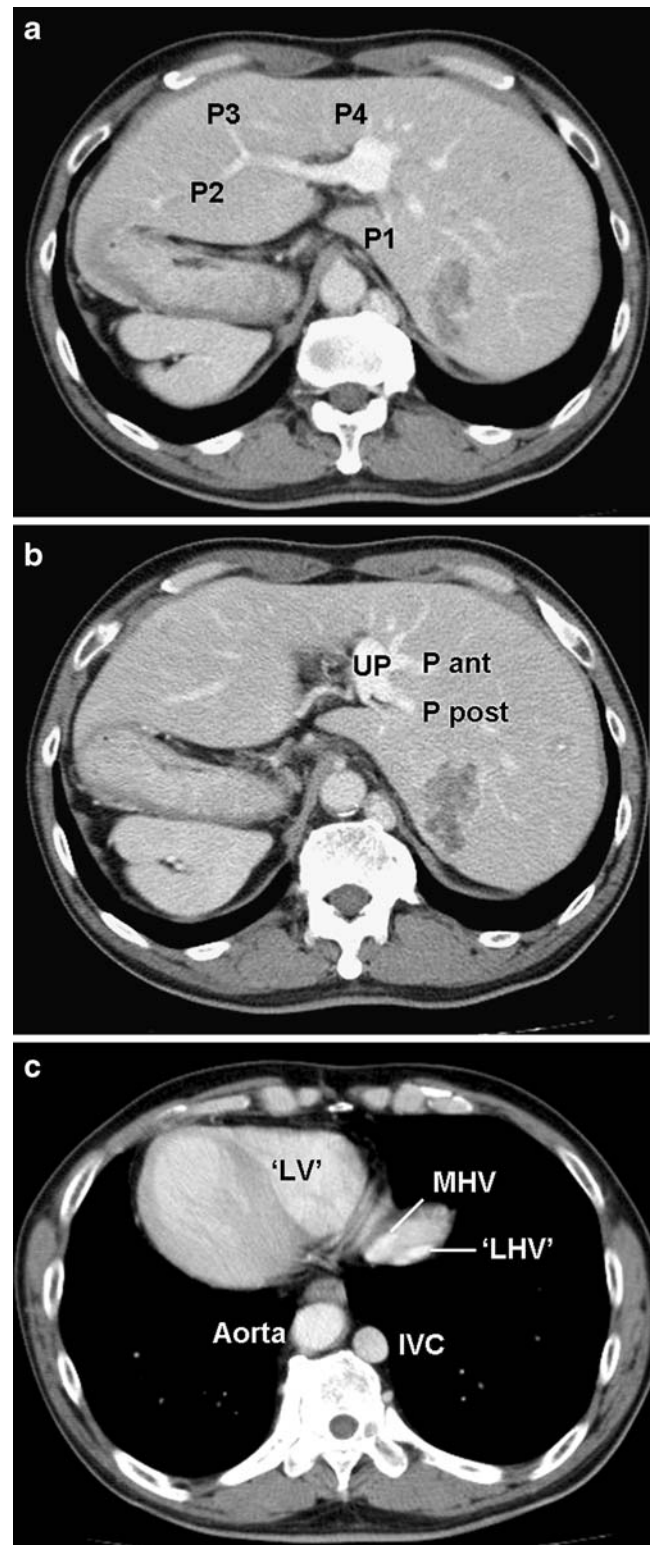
a, b Enhanced abdominal CT shows that the umbilical portion is “left”-sided with total ramification of the intrahepatic portal branches from that section. The umbilical portion is characterized by a *saccular shape*. *P ant* anterior branch of portal vein, *P post* posterior branch, *P1* Caudate lobe branch, *P2* “left” lateral posterior branch, *P3* “left” lateral anterior branch, *P4* left medial branch. c Hepatic veins drain directly to the “left” atrium but not to the inferior vena cava. “LV” “left” ventricle, IVC inferior vena cava.
